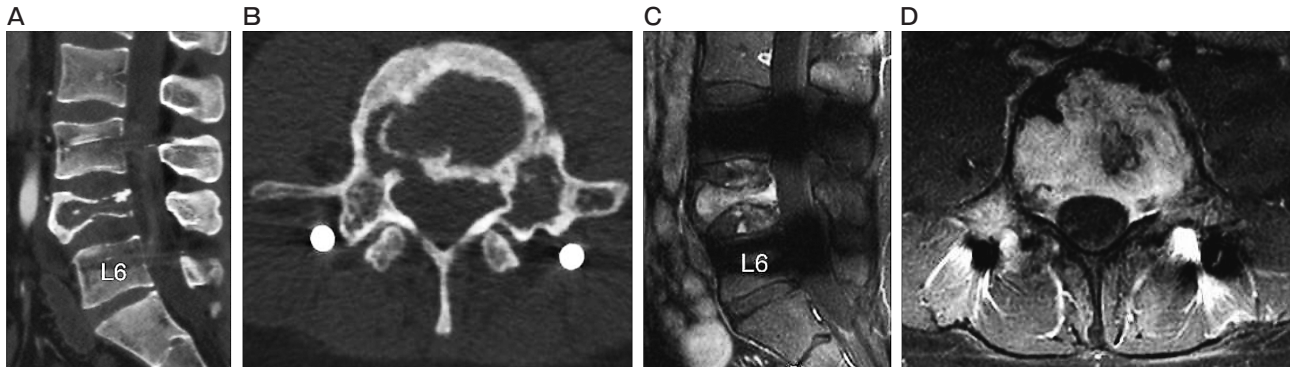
Computed tomography scan after 6 months of denosumab therapy revealing calcification of the affected vertebra (A, B). Gadolinium-enhanced T1-weighted magnetic resonance image showing shrinkage of the tumor and no canal occupation (C, D).
